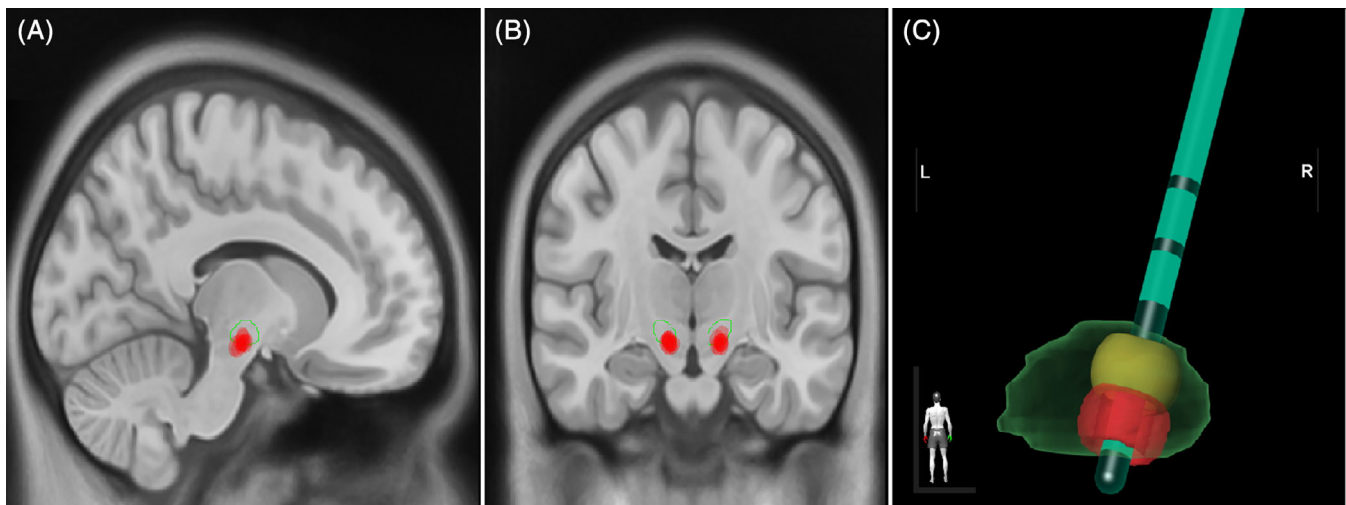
Volume of tissue activated (VTA) with the stimulation of the most ventral contact and tridimensional representation of the theta-gamma stimulation of the subthalamic nucleus. Sum maps representing the number of overlapping VTAs (red circles) when stimulating the most ventral electrode contact are shown overlaid on sagittal (A) and coronal (B) slices of a T1 standard magnetic resonance imaging brain template. The STN are represented with green outlines. (C) A tridimensional sample of the VTA obtained with simultaneous stimulation of the right STN in two contacts of the same lead (1- with red sphere, and 567- with yellow sphere) from one patient in our cohort, obtained through the software Stimview XT (Boston Scientific, Valencia, CA, USA). L, left; R, right. [Color figure can be viewed at wileyonlinelibrary.com]
